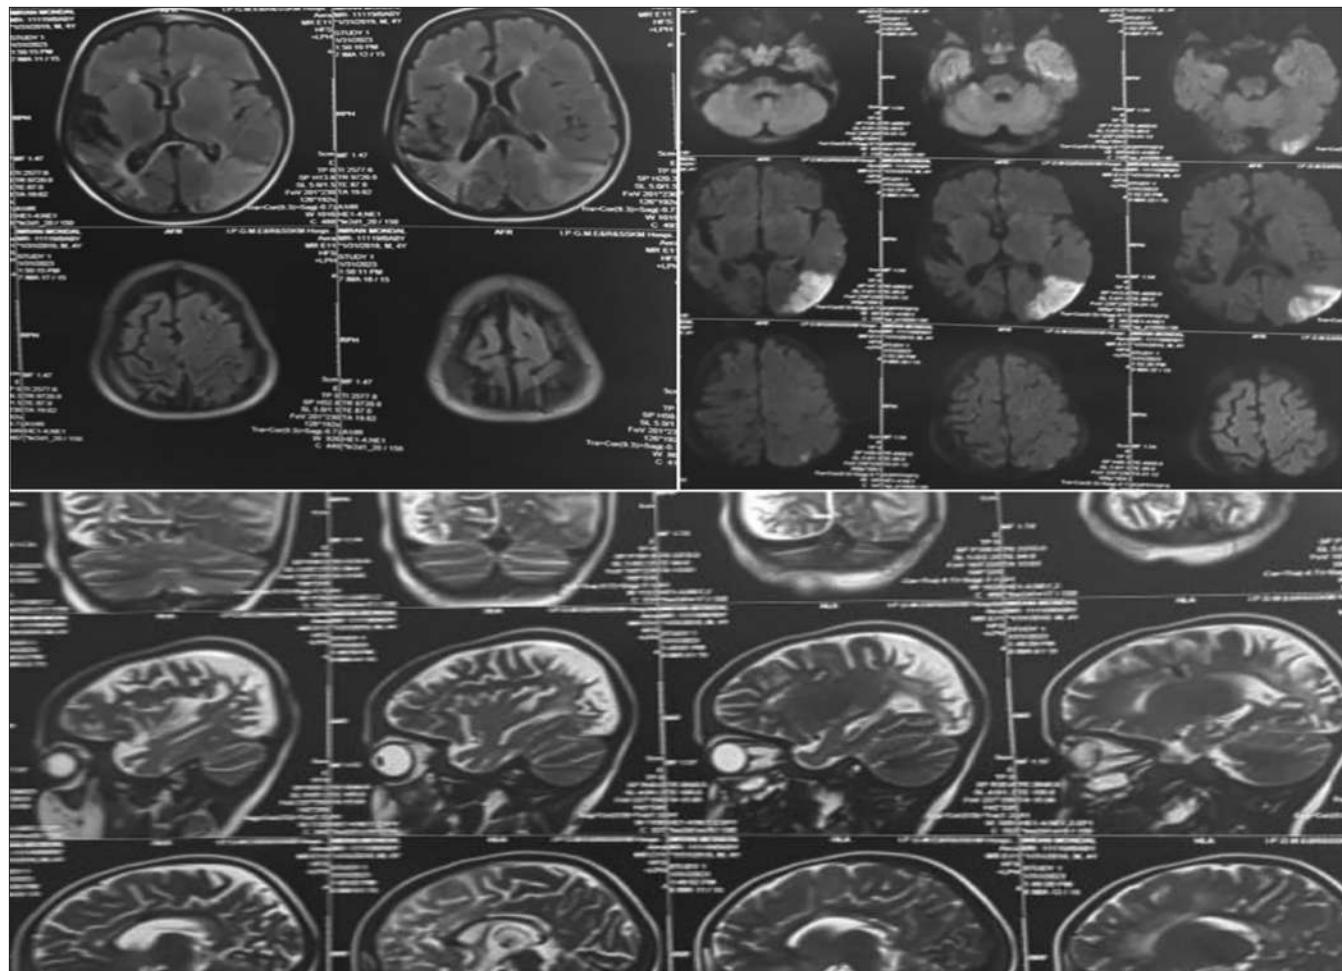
MRI Brain (contrast) Coronal and sagittal view: Large area of diffusion restriction in DWI with T2 weighted hyperintensity involving left parieto-occipital lobe s/o acute infarct. Diffuse moderate gliosis and atrophy seen involving lower lobes of right cerebral hemisphere. Old infarct not showing any enhancement in post contrast study seen in right parieto-temporal region
